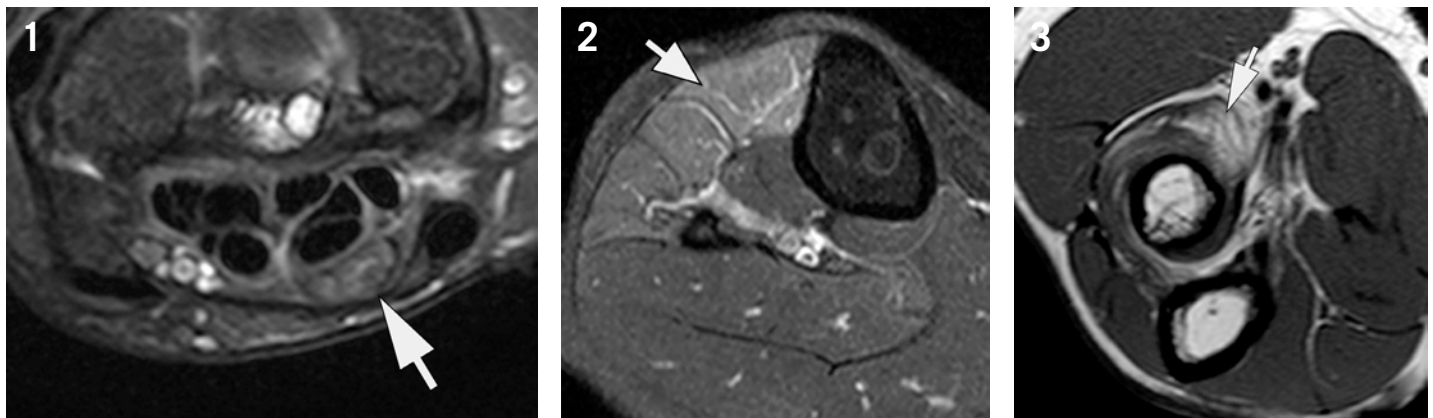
Neuropathy of the median nerve. Axial T2-weighted fat-suppressed image of the wrist depicts thickening of the median nerve, slightly increased signal, and loss of the normal fascicular pattern (arrow).
